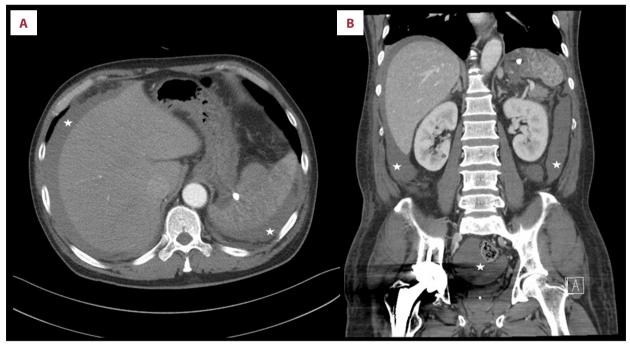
Contrast-enhanced computed tomography (CT) of the abdomen three days after angio-embolization. Contrast-enhanced axial (A) and coronal (B) abdominal computed tomography (CT) scans show no evidence of splenic artery hemorrhage and slightly reduced hemoperitoneum (white star).
